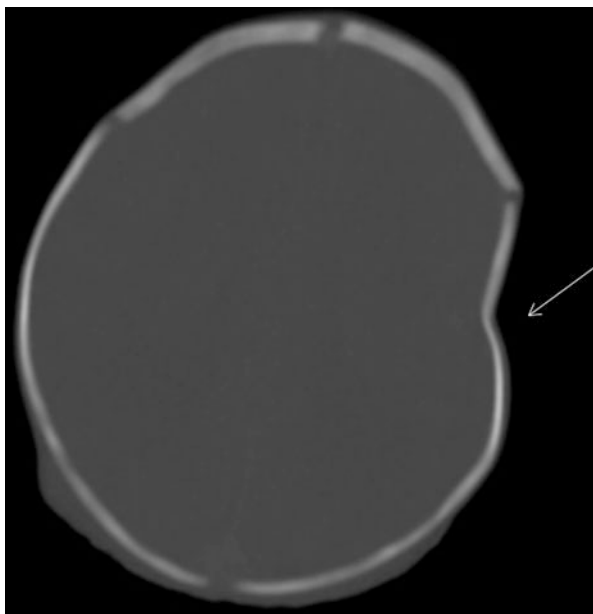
Axial CT showing depressed left parietal skull fracture (*arrow*) (Image courtesy of Tara Holm, MD)
